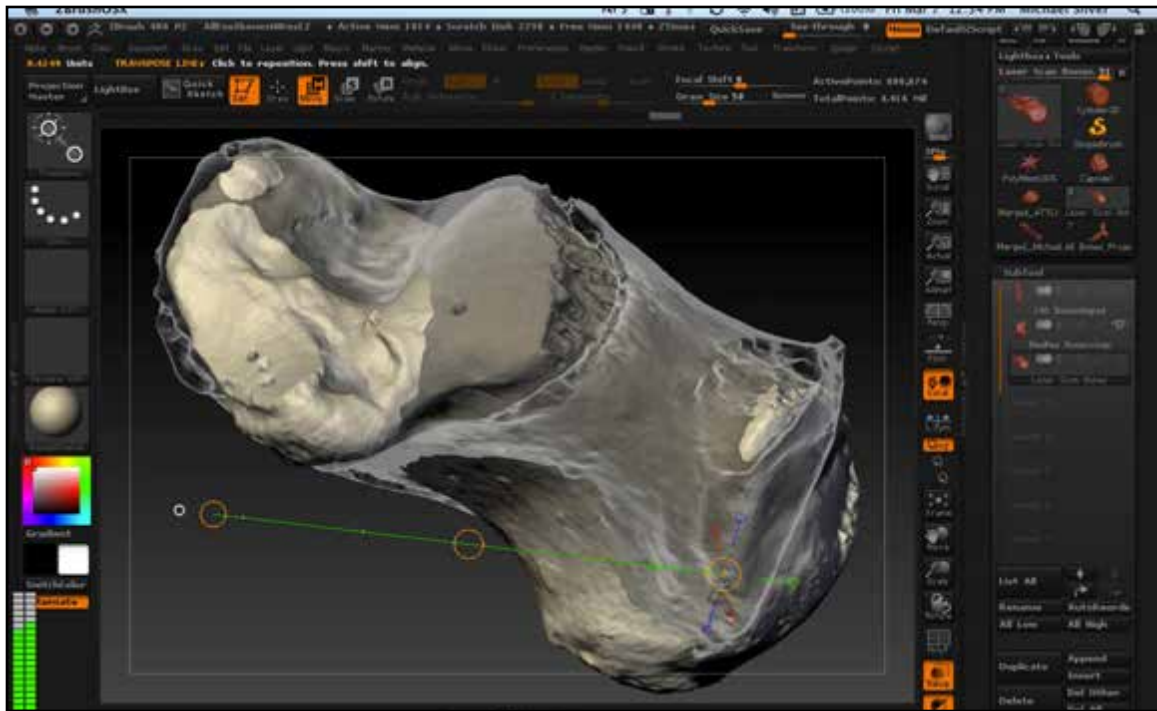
Aligning laser scan data mesh with CT based mesh using Transpose tool.
